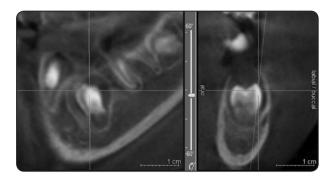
Six months CBCT follow up showing marked regression in the size of the cystic lesion and new bone formation was evident.
